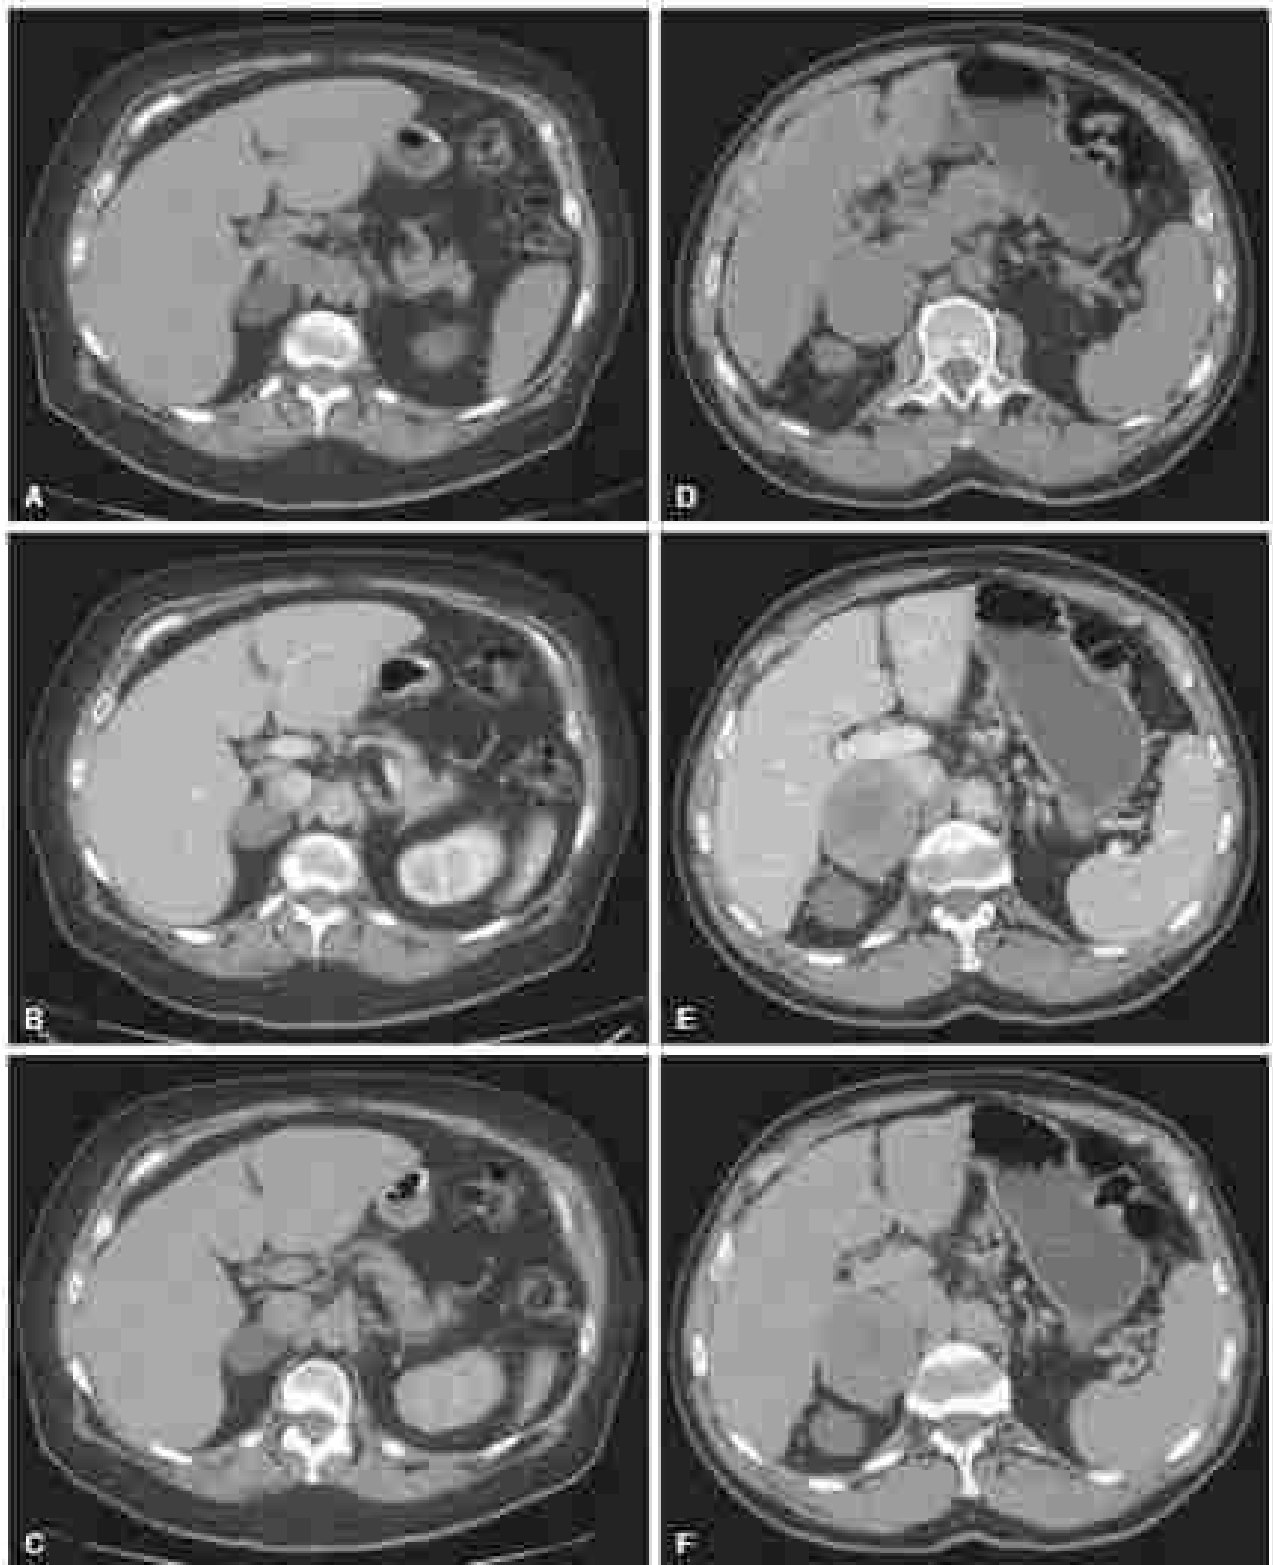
Cross-sectional computed tomography scans showing a large aneurysm and an retroperitoneal carcinoma. (A) Noncontrast image of a large aneurysm showing a diameter of 4.5 cm with a low attenuation of -11 HU. (B) Contrast-enhanced computed tomography scan (portal vein phase) showing rapid contrast uptake with attenuation of 111 HU. (C) Contrast-enhanced computed tomography scan (portal vein phase) showing rapid contrast washout with attenuation of 62 HU. (D) Noncontrast image of an retroperitoneal carcinoma showing a high attenuation lesion (61 HU). (E) Contrast-enhanced computed tomography scan (portal-venous phase) of an retroperitoneal carcinoma showing a hypoenhancing lesion with attenuation of -24 HU. (F) Contrast-enhanced computed tomography scan (portal-venous phase) showing slow contrast washout with attenuation of 71 HU. (portal-contrast washout of 7 HU).
